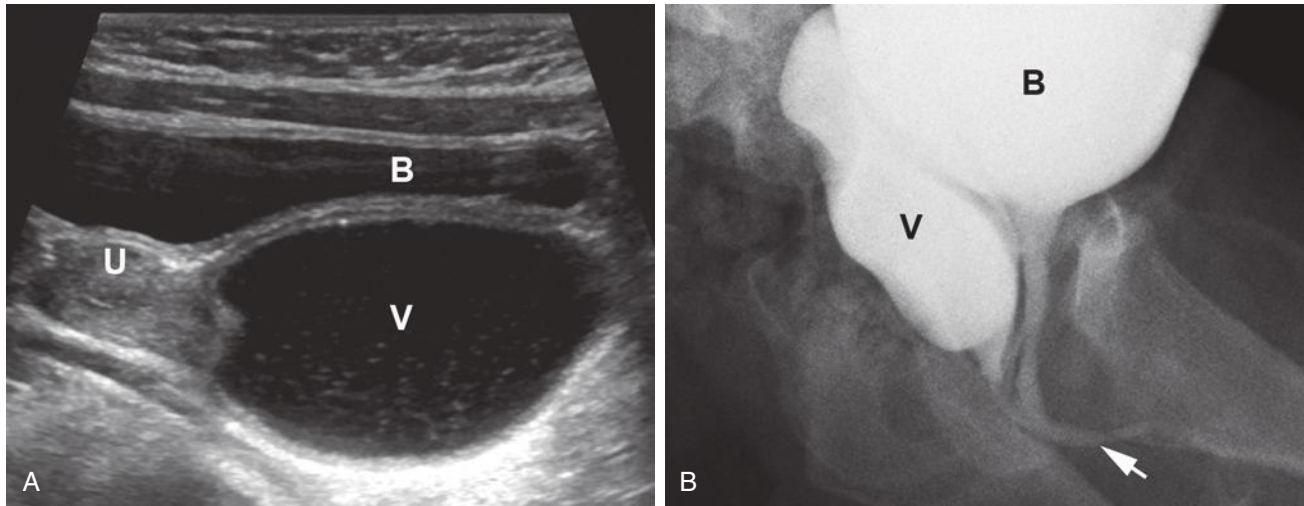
Congenital adrenal hyperplasia in a 13-year-old girl with a single opening on the ventral aspect of an enlarged clitoris. A, Sagittal ultrasound image demonstrates a dilated, fluid-filled vagina (V) that compresses the posterior aspect of the bladder (B). The uterus (U) appears normal. B, Sagittal image from voiding cystourethrography. There was retrograde filling of the vagina (V) from the bladder (B). The distal vagina and urethra unite to form a common perineal channel (arrow).
